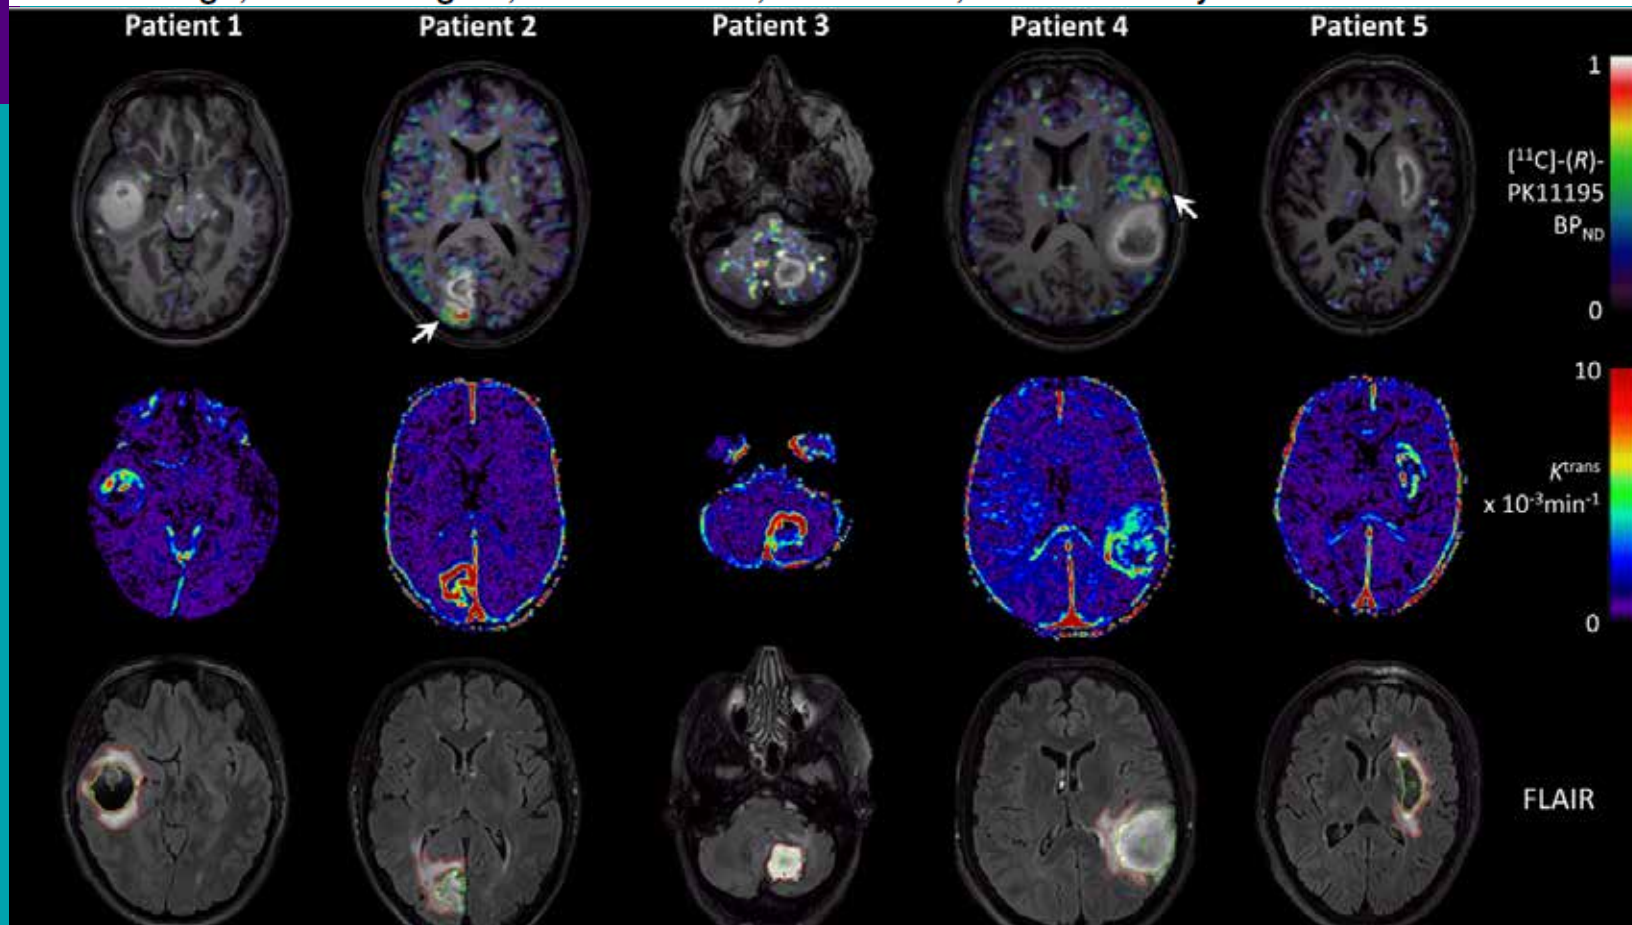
Representative parametric maps of $[^{11}\text{C}]-(R)\text{-PK11195}$ PET binding potential (BP_{ND}) (superimposed on to T_1 -weighted images) and volume transfer constant (K^{trans}) with fluid-attenuated inversion recovery (FLAIR) images from each patient with regions of interest for hematoma (green) and edema (red). Increased $[^{11}\text{C}]-(R)\text{-PK11195}$ binding is indicated in patients 2 and 4 by arrows.
